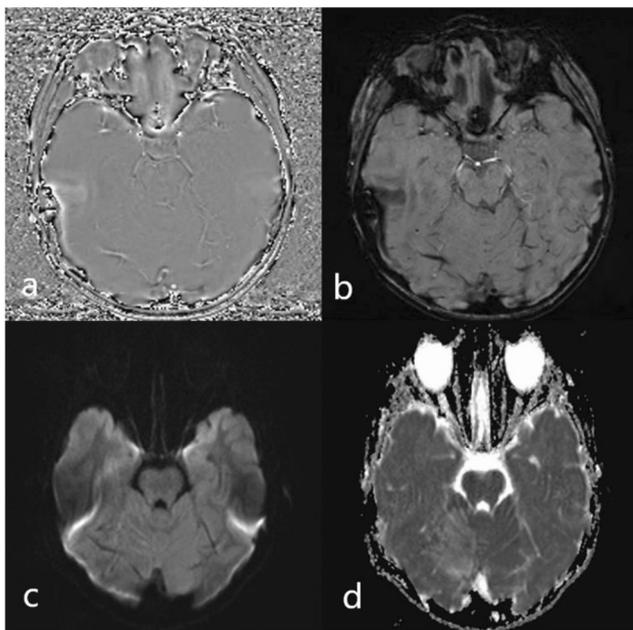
Susceptibility and diffusion weighted imaging (SWI and DWI) of intracranial juvenile xanthogranuloma. Phase (a) and SWI (b) images does not reveal obvious abnormalities within the lesion. It was isointense on DWI (c, b = 1000) and slightly hyperintense on apparent diffusion coefficient (ADC) map (d)
